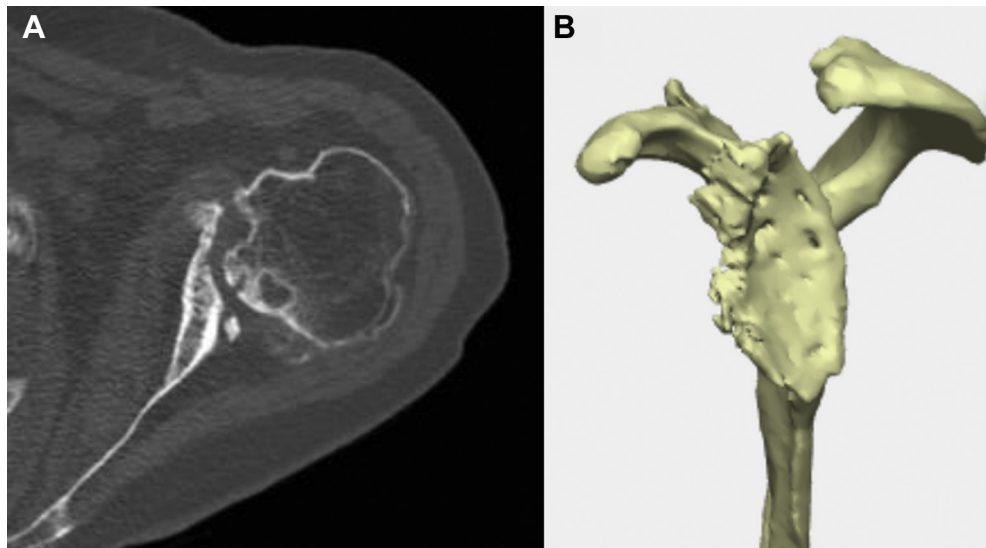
(A) Axial computed tomography scan showing severe glenoid bone loss, medialization, and small window of bone in glenoid vault available for baseplate fixation. (B) Three-dimensional reconstruction of same glenoid with severe bone loss.
